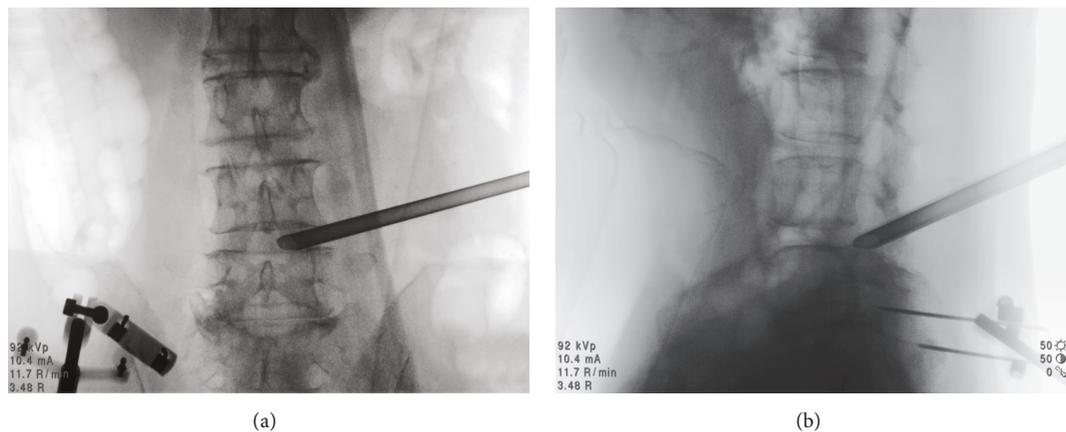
The anteroposterior (a) and lateral (b) fluoroscopy views of intraoperative radiograph after the working cannula placed.
